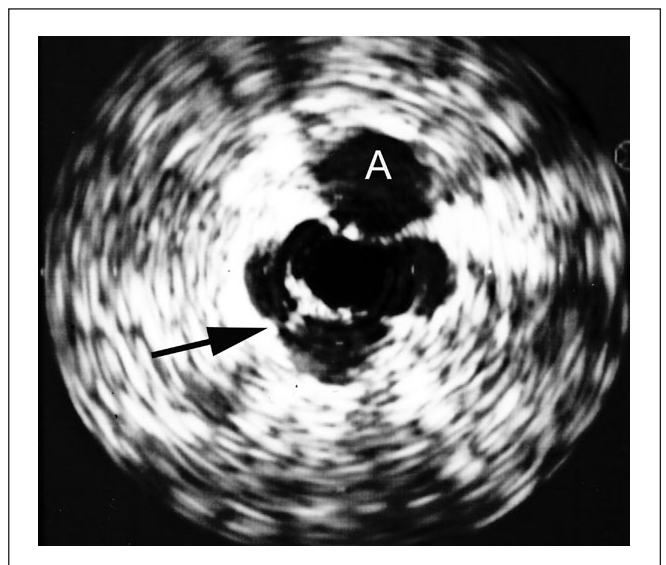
Intravascular ultrasound (IVUS) showing trabeculation (arrow) not visualized by phlebogram. The adjacent artery is marked with an A.
